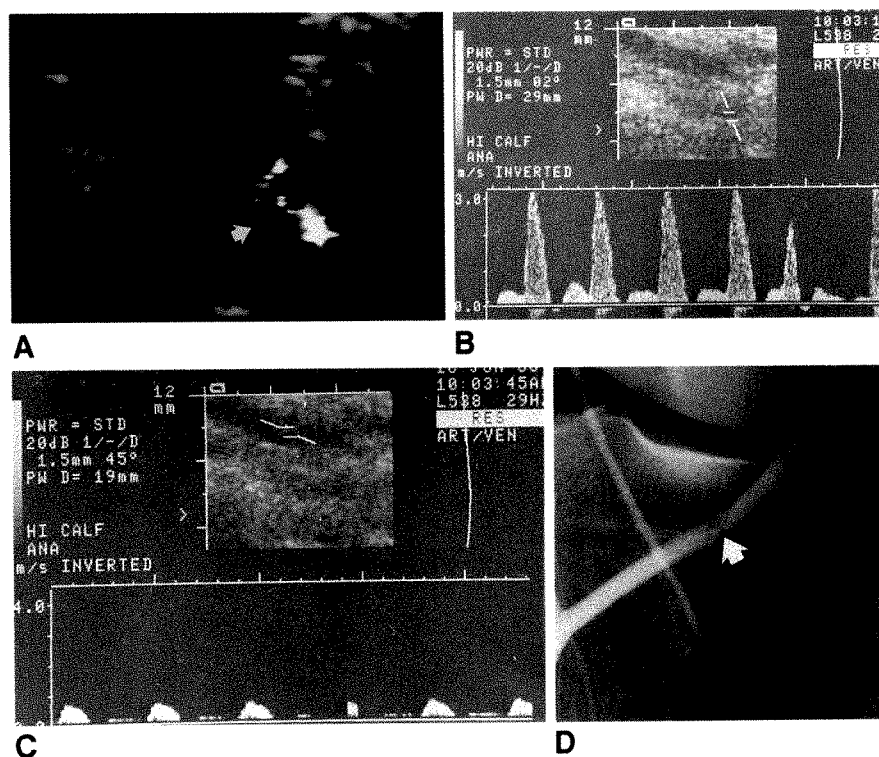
Value of color Doppler imaging near distal graft anastomosis is shown in this 63-year-old man with a femorotibial graft. Difficulty in clearly identifying graft lumen on gray-scale image is abated by use of color Doppler image.
